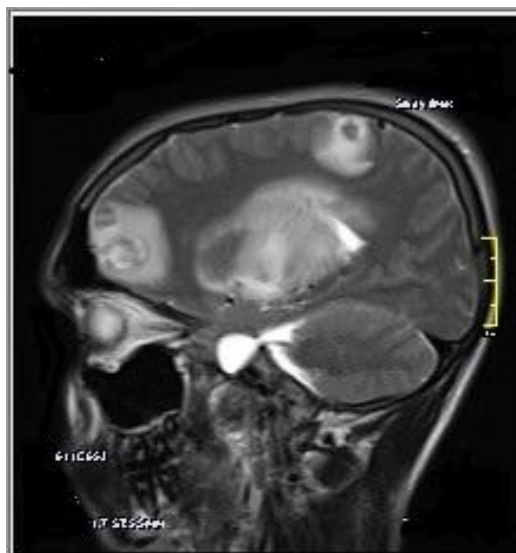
Cranial lesion due to Toxoplasmosis in sagittal MR image
